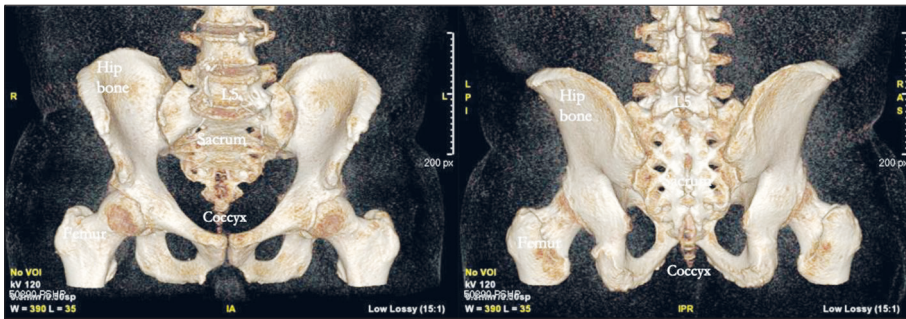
3D CT-scan of the pelvic bones. Anterior (left) and posterior (right) view of the pelvic bones.
